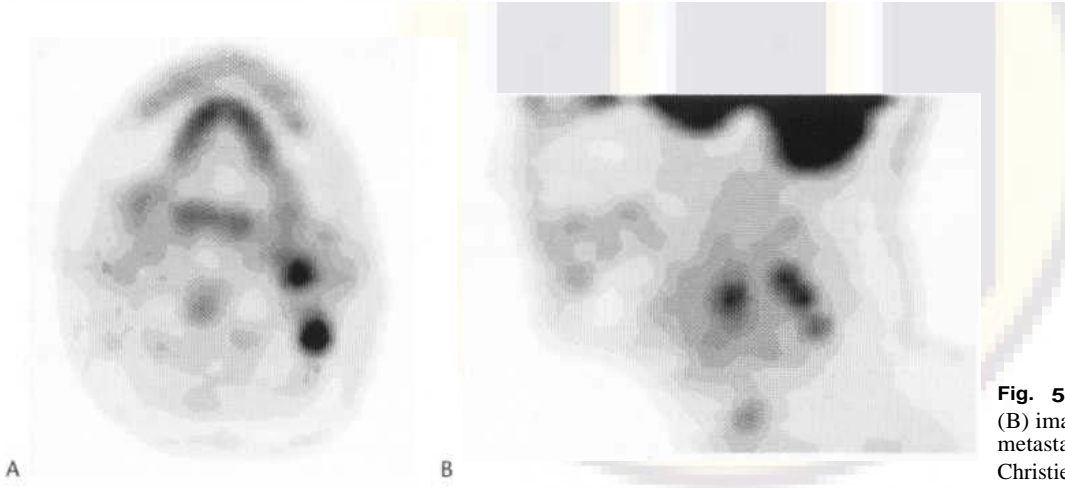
FDG-PET axial (A) and sagittal (B) images in a patient with small volume nodal metastases in the neck. (Courtesy of Dr P. Julyan, Christie Hospital, Manchester.)
